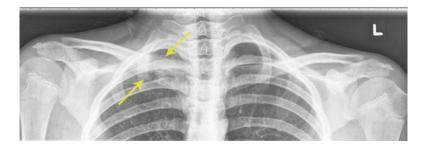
Proximal clavicular expansion and irregularity on plain radiograph in a 13-year-old boy with CRMO (arrows)
